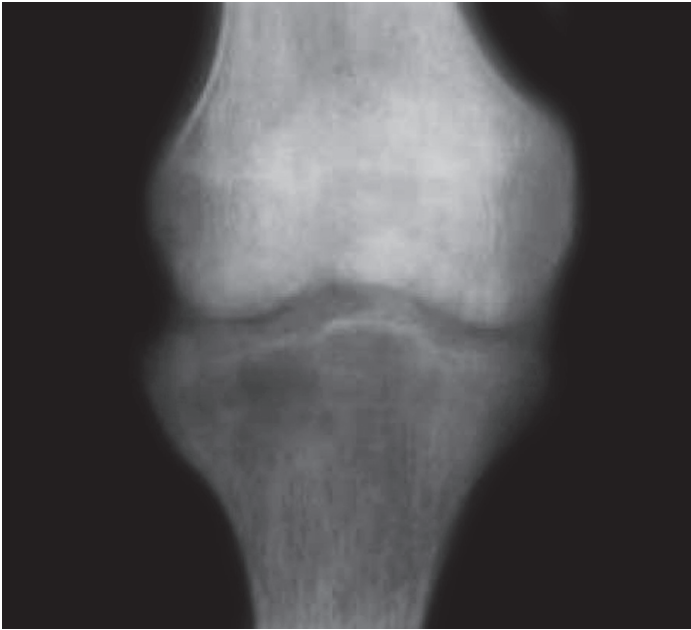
X-ray shows septic arthritis²
